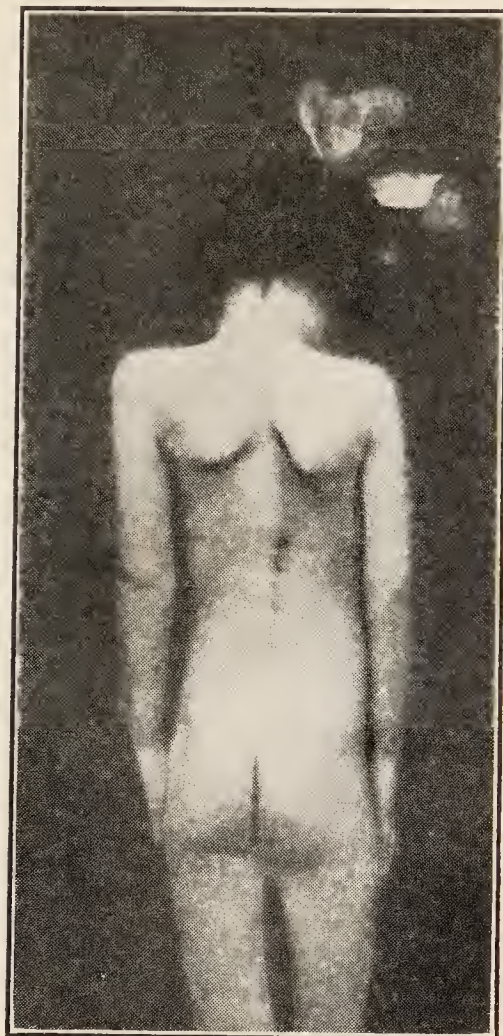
Scoliosis from infantile paralysis after six months' treatment by forcible plaster jackets (same case as Fig. 64; x-rays are shown in Figs. 66 and 67).
